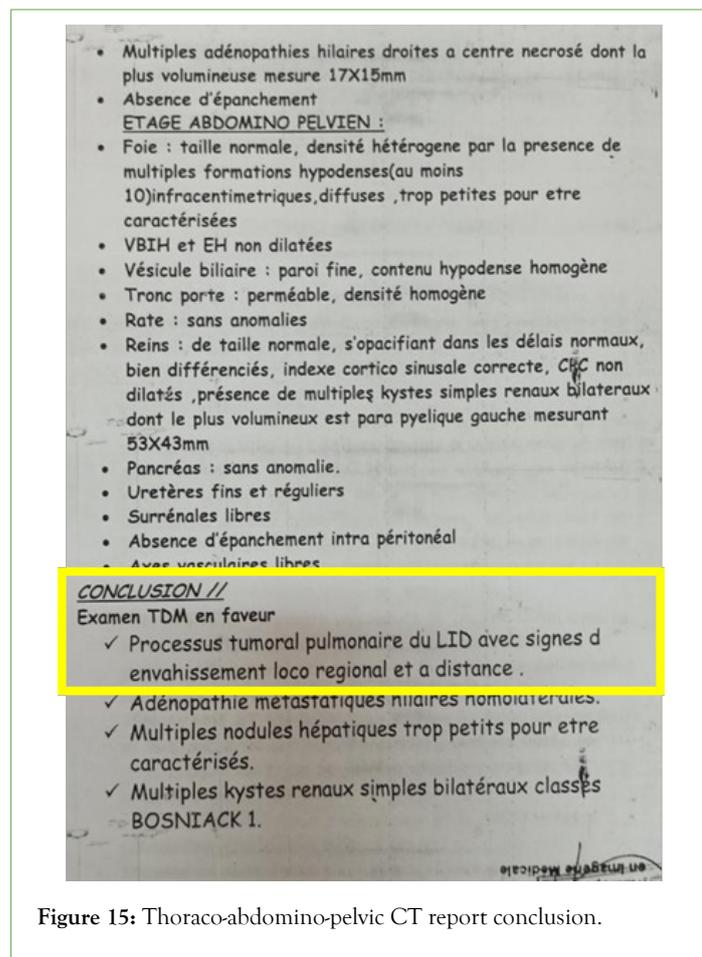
Thoraco-abdomino-pelvic CT report conclusion.
